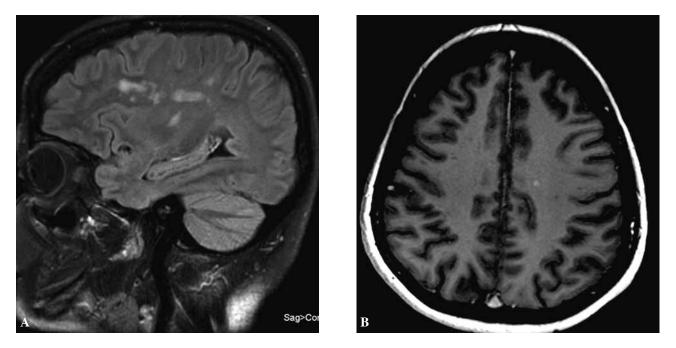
Brain MRI (left) flair coronal sequence showing lesions perpendicular to corpus callosum; (right) T1 postcontrast transversal sequence showing one enhancing lesion.
